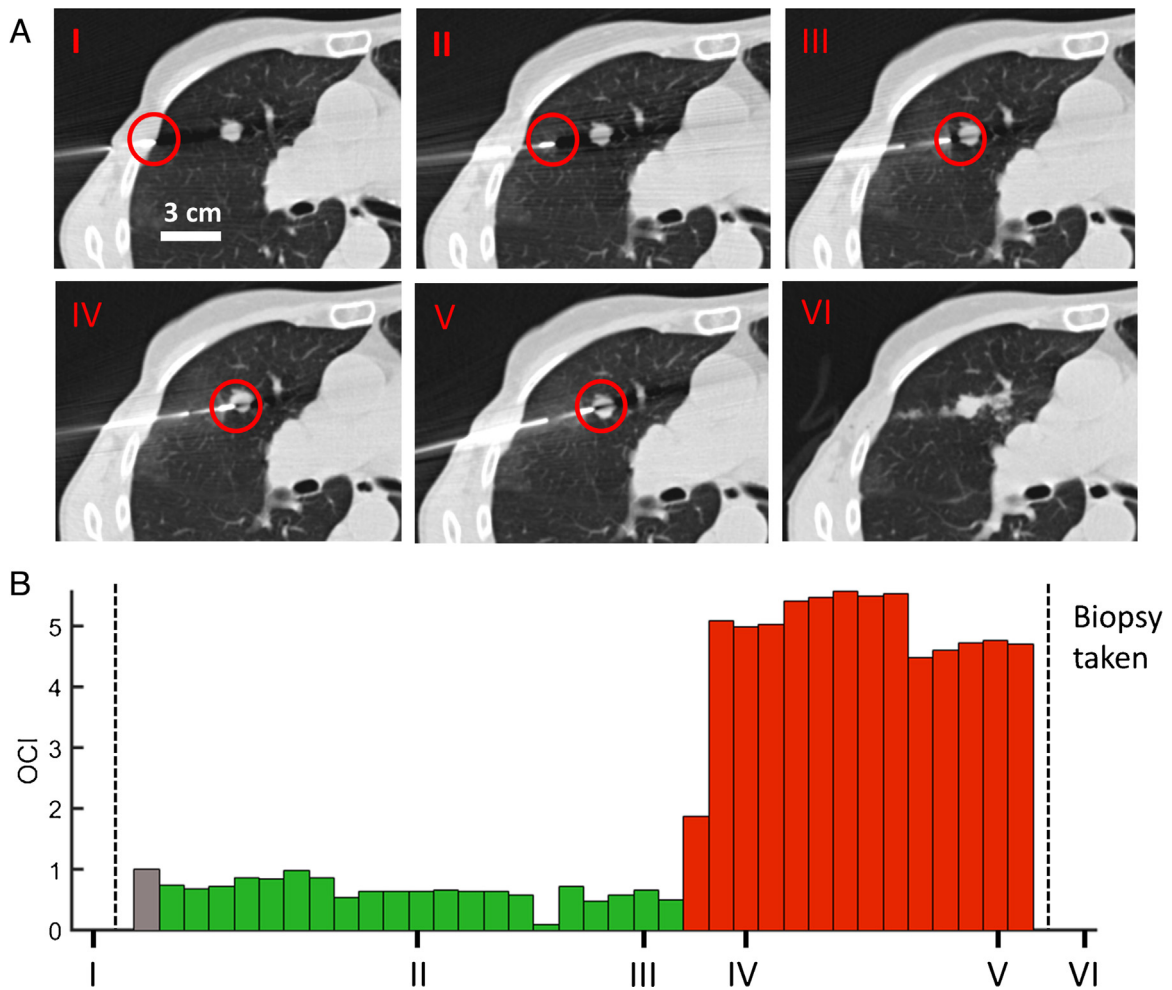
Real time tissue characterization and biopsy with the FOBN in an individual. (A) CT Fluoroscopy images during insertion of the FOBN (images I through V) and after the biopsy has been performed (image VI). (B) The OCI was extracted from the optical data along the needle path. Note that the first measurement in lung parenchyma served as internal reference.
